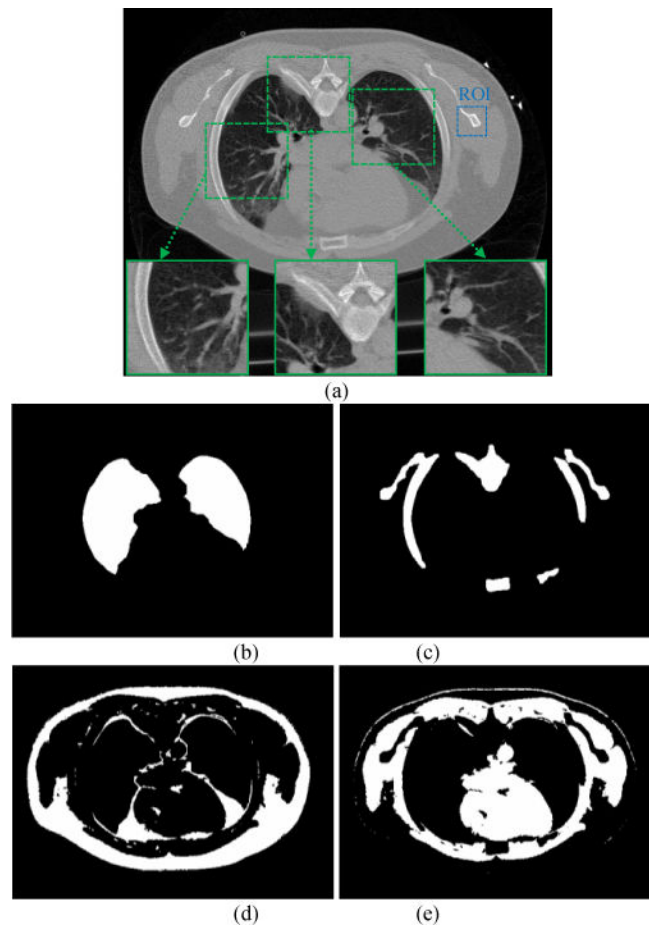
Segmented masks of the chest CT image (a). Picture (b) is the lung mask or region; (c) is the bone mask; (d) is the fat mask; and (e) is the muscle mask.
